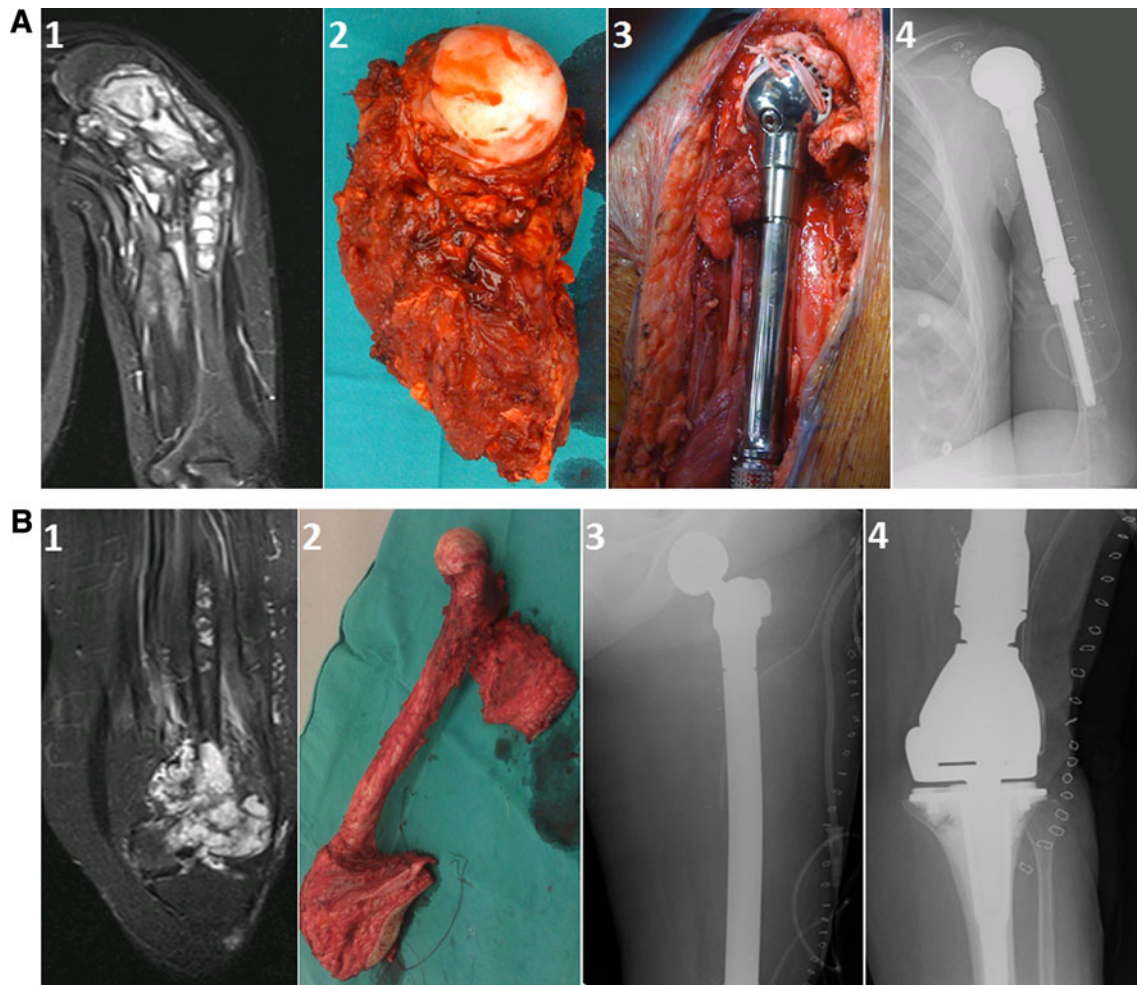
a 14-year-old boy presented with pain, swelling and restricted range of motion of the left shoulder. 1 MRI showed pathological fracture of the humerus and a mass (later, biopsy-proven osteosarcoma); 2 resected humeral head; 3 proximal humerus prosthesis. 4 Post-operative X-ray showing left shoulder proximal humerus
